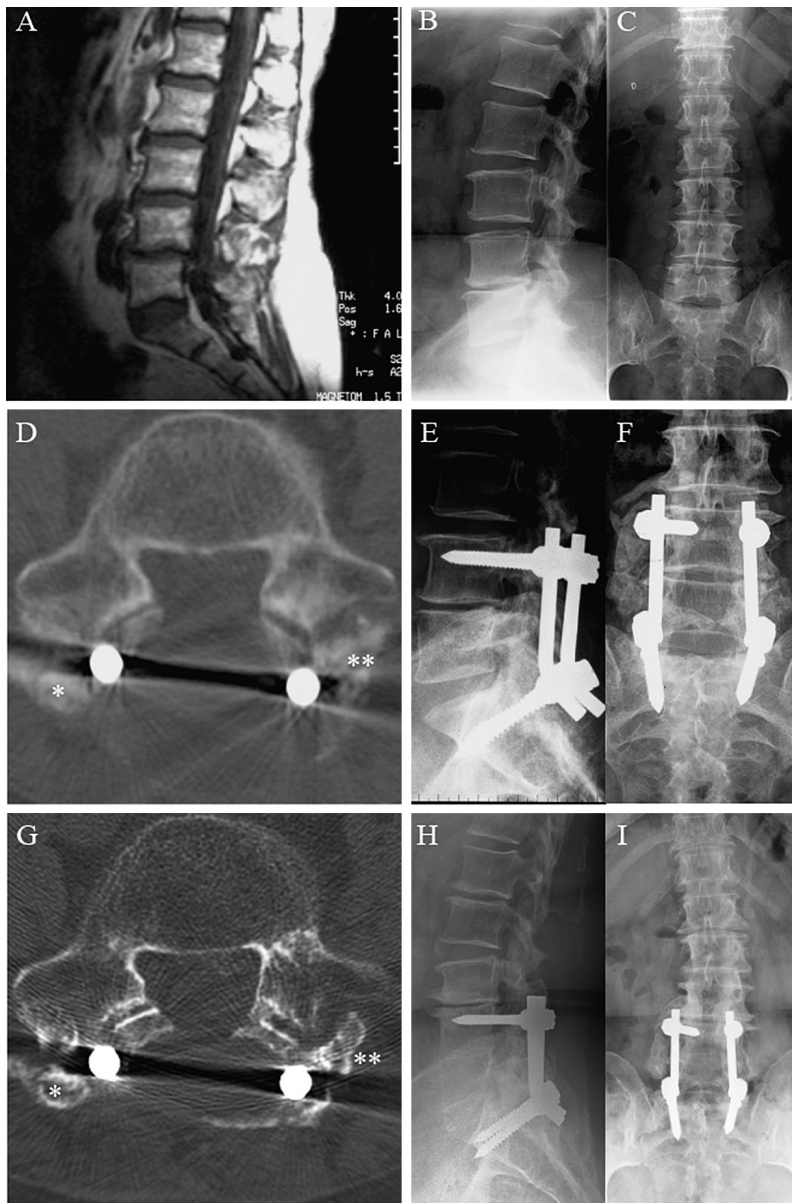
(rtg/CT/MRI). The patient is a 76-year-old female treated for L4/5 degenerative spondylosisthesis with instability symptoms and radicular pain in the lower extremities.
